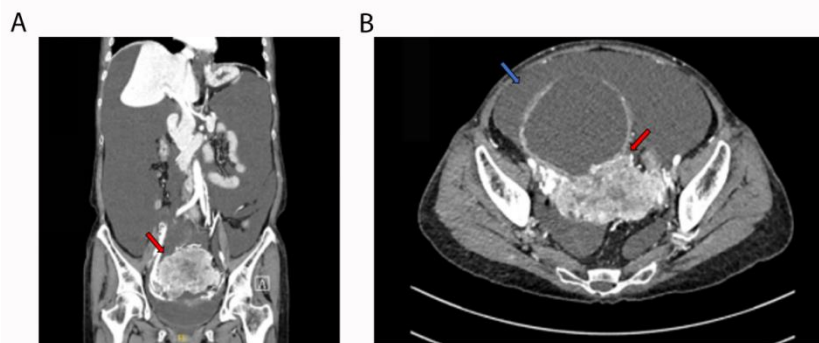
Computed tomography (CT) imaging before surgery. A) Coronal CT image. Cystic and solid mixed masses (indicated by red arrows) can be seen in the bilateral adnexa, with a size of approximately 16.8×14.5×10.3 cm. B) Axial CT images. A large amount of effusion can be seen in the abdomen and pelvis (indicated by the blue arrow).
